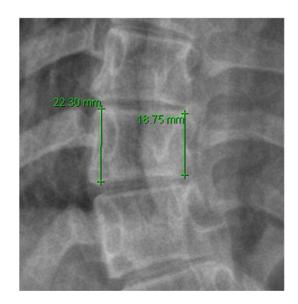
These radiographs are of a patient with curve progression and increased vertebral wedging as shown by (A) a pre-brace T10 apical ratio of 1.1 (convex height of 18 mm and concave height of 16 mm) and (B) a post-brace T10 apical ratio of 1.2 (convex height of 22 mm and concave height of 19 mm).
